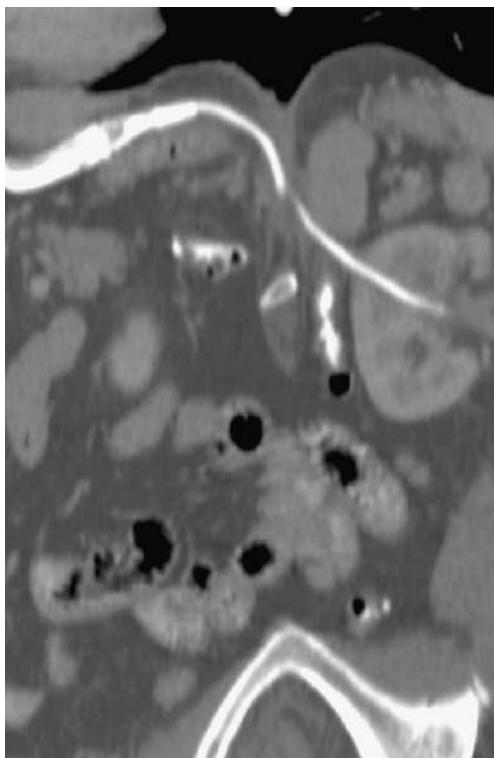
Reconstruction image of the abdominal CT scan showing intrarenal penetration of the connection tube. The gastric band is seen. Penetration is shown in two directions ending in the hilus of the left kidney
